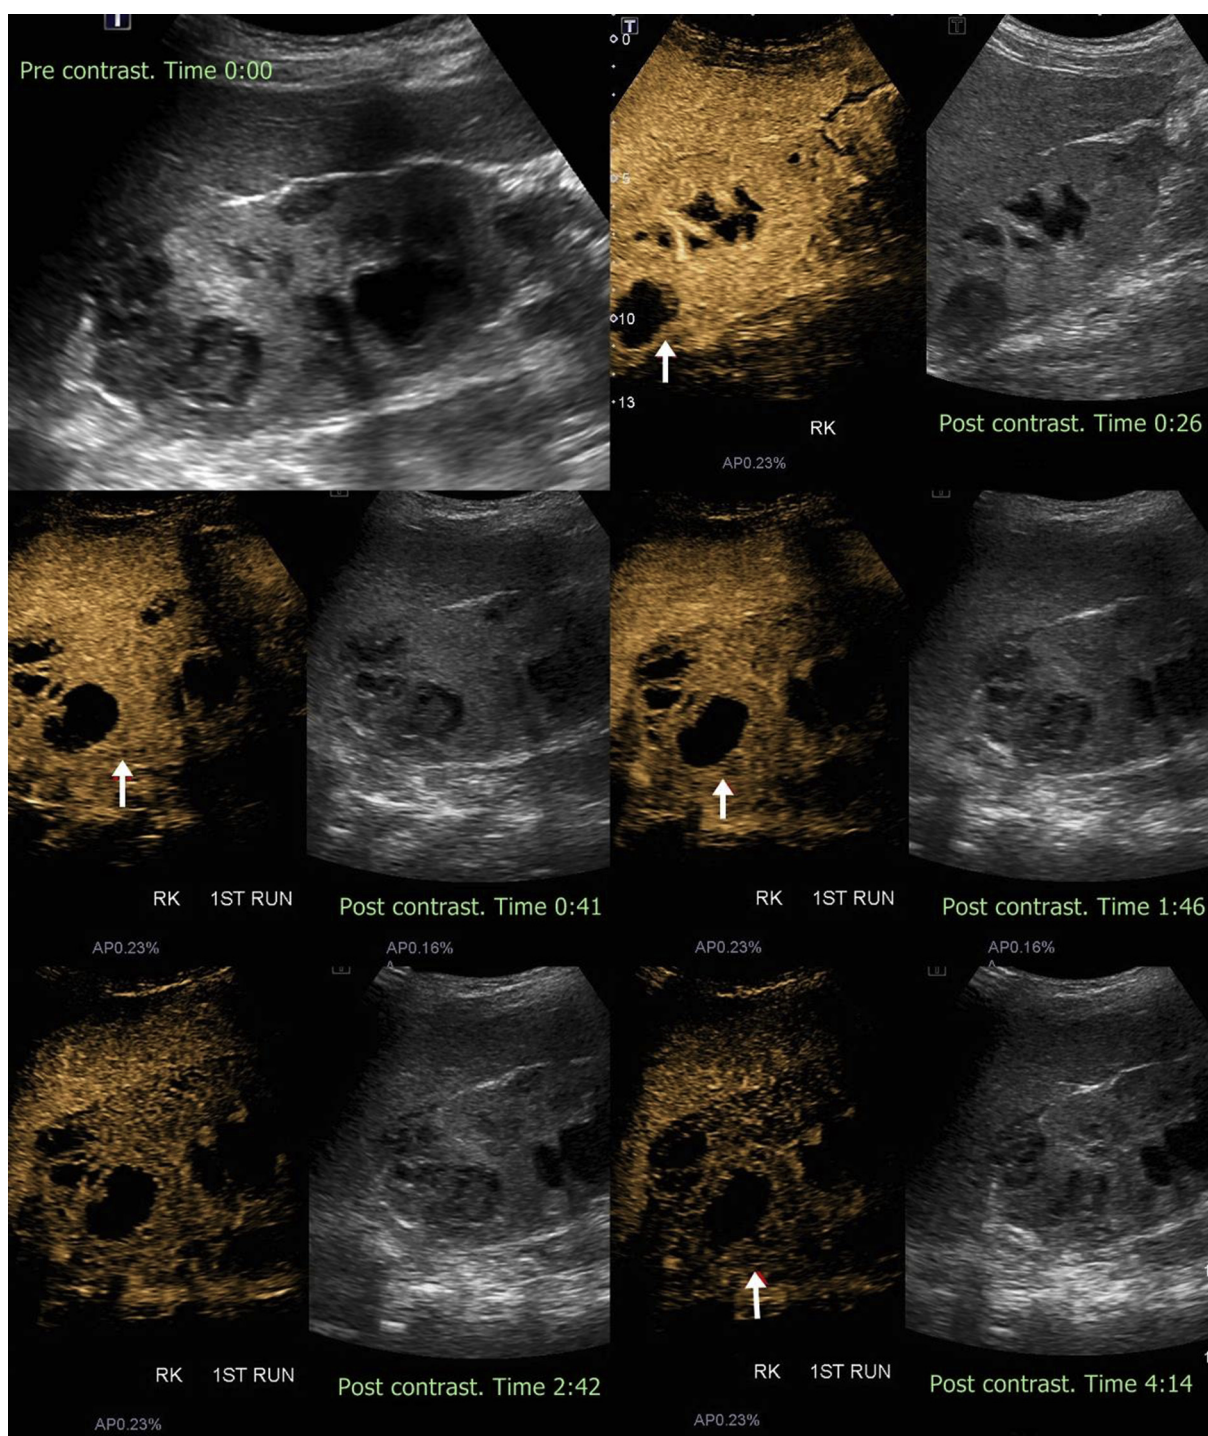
Renal abscess. A 10-year-old boy being treated for recurrent urinary tract infection. Bedside ultrasound is performed to look for secondary renal findings, due to persistent high fever (38°C), and elevated C-reactive protein markers. Noncontrast images show a heterogeneous hypoechoic lesion. After contrast-enhanced ultrasound, there is a prompt enhancement of the periphery of the lesion (arrow), with no central enhancement and no delayed washout. The enhancement timing is similar to the rest of the renal parenchyma.
